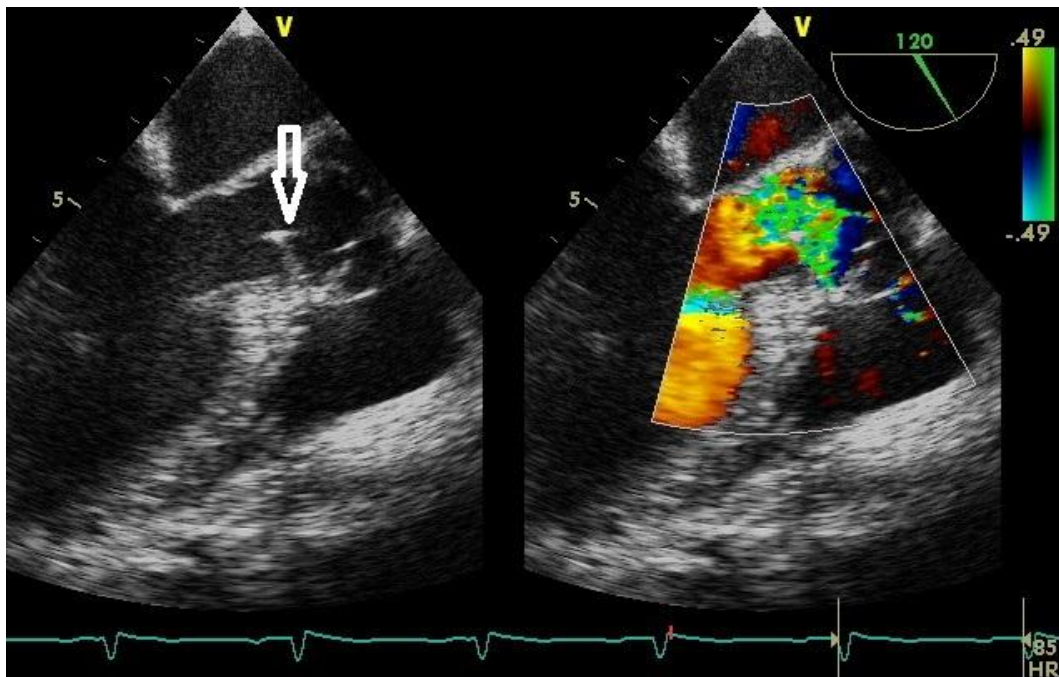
TEE showing fibrous membrane in LVOT just below the aortic valve and turbulence in LVOT across the membrane on colour Doppler (120° view)
